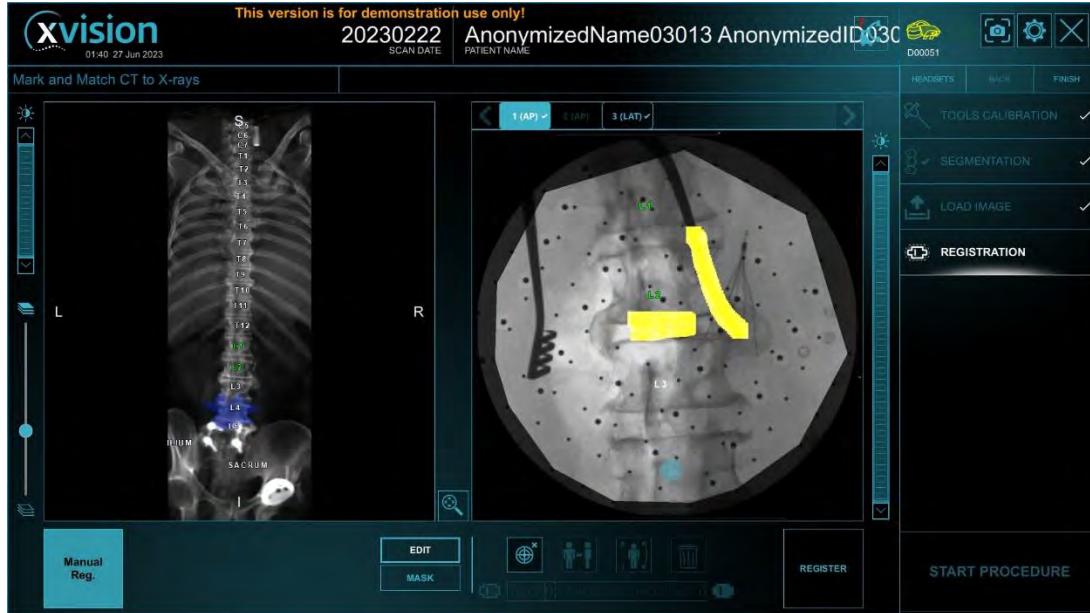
Manual Registration - Confirm desired level on CT and FLUORO Reference Windows
